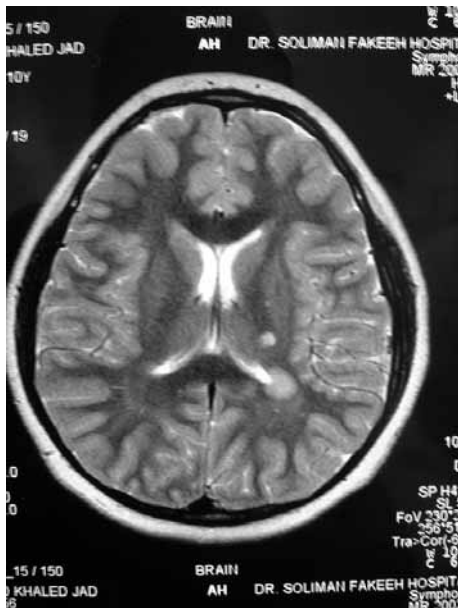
Brain MRI showing multiple well-defined asymmetrical hyperintense T2 lesions in the periventricular and subcortical white matter.
